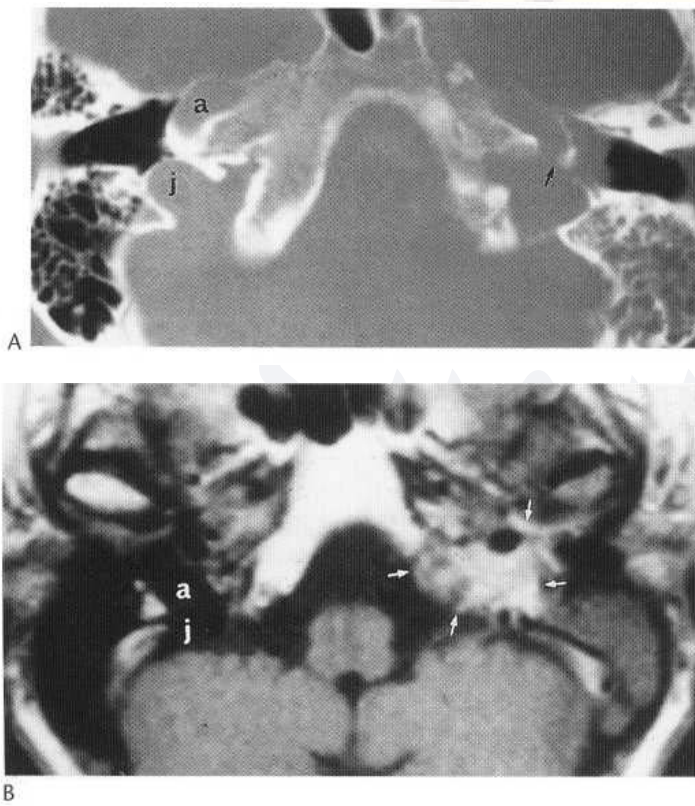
(A) Base CT at the level of jugular fossa (j) and horizontal carotid canal (a). On the right the crest of bone between them is apparent. On the left this part of the jugular fossa is eroded by a glomus jugulare tumour (arrow), which has also extended into the middle ear. (B) Base Gd-MR scan at the same level, showing the tumour surrounding the carotid artery and quite distinct from the fluid in the mastoid.
